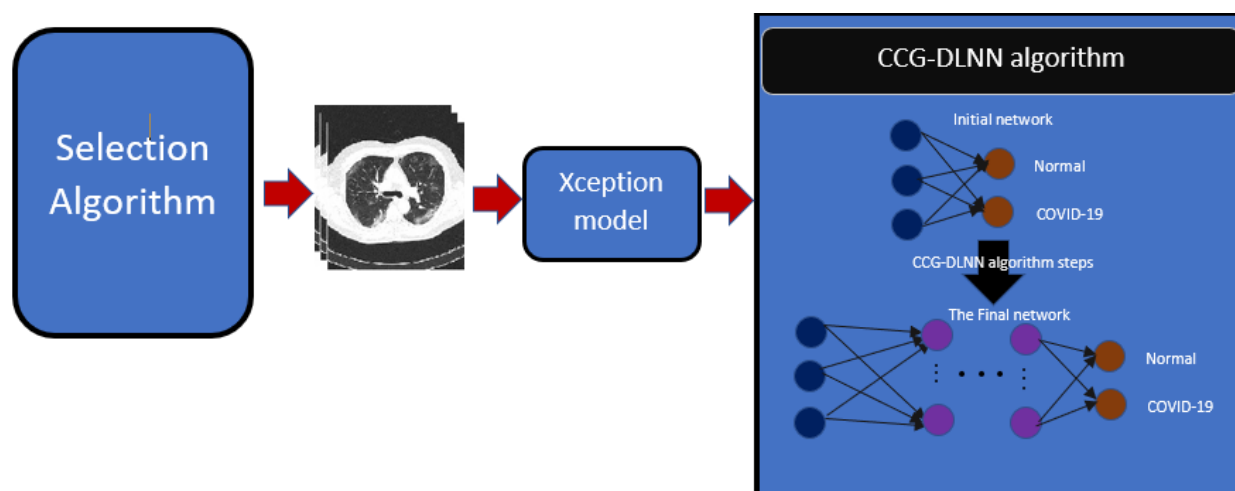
CT scan COVID-19 classification system
